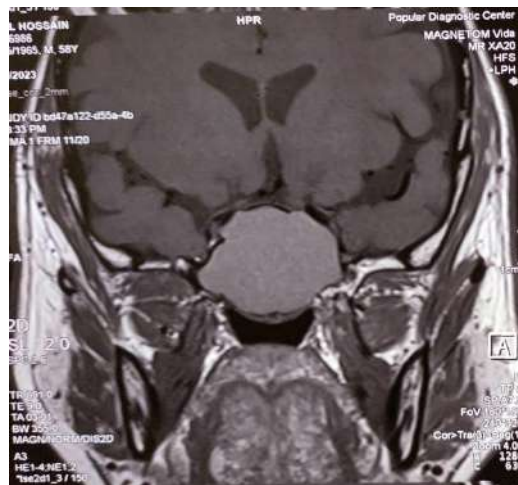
MRI Brain T 1 image Coronal view
